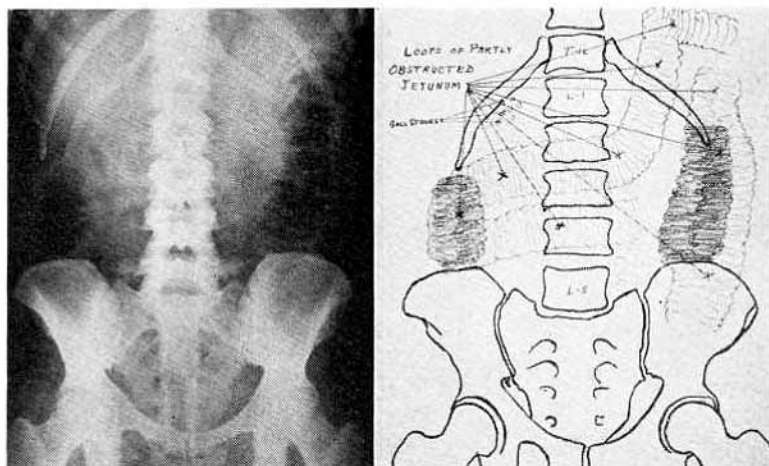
Case II. Ventral projection of abdomen, patient prone. The patient, Mrs. E. F., aged thirty-two years, has had attacks characteristic of gallstone colic, but no present clinical symptoms suggestive of high intestinal obstruction. The abdomen is soft. There is fever with oscillation from 99° to 102° F. The blood picture is essentially normal, except for a very slight shift to the left in the differential white blood count. On the basis of the present roentgenogram a definite diagnosis of partial obstruction at middle of small intestine is made. The gallbladder is full of gallstones which are visualized by their opaque centers.
